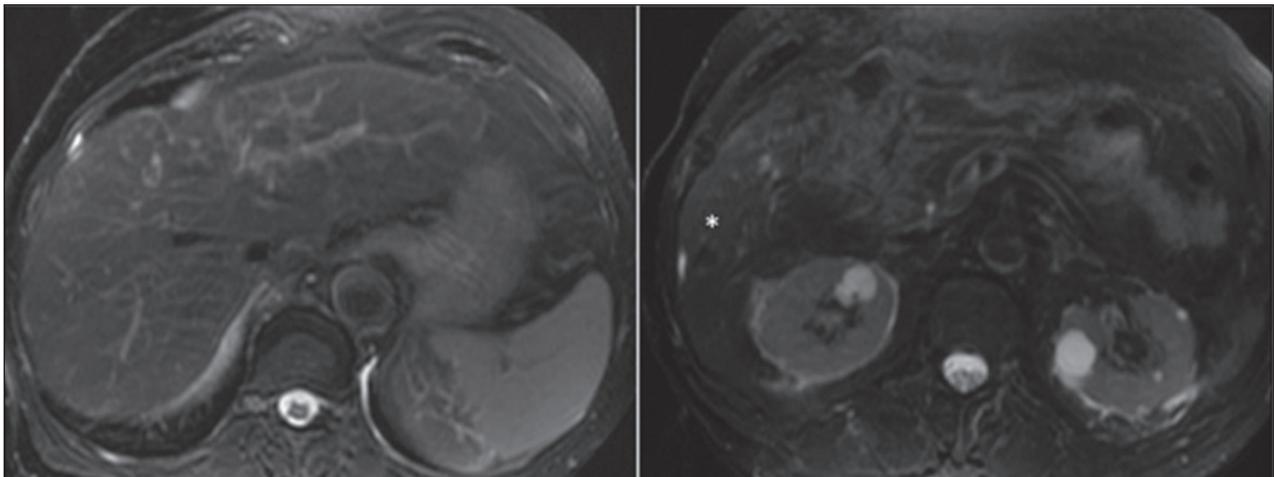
Axial T2 weighted Liver MRI images obtained three months after the end of DAA treatment. The area previously ablated (*) does not show radiological signs of tumor persistence. No other liver lesions are seen.
